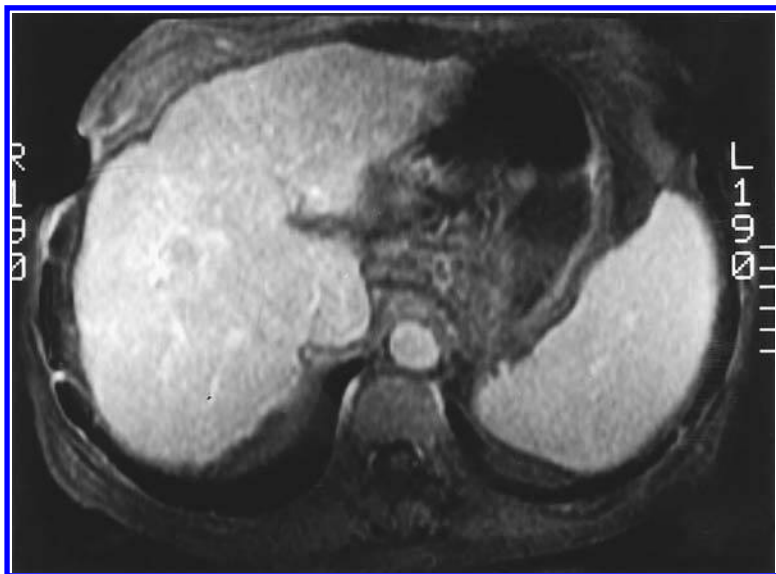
Magnetic resonance imaging (MRI) of small hepatocellular cancer.
